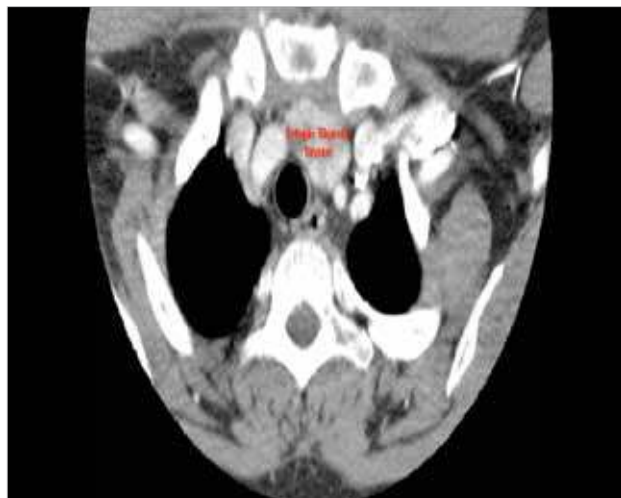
Image of CT-scan
